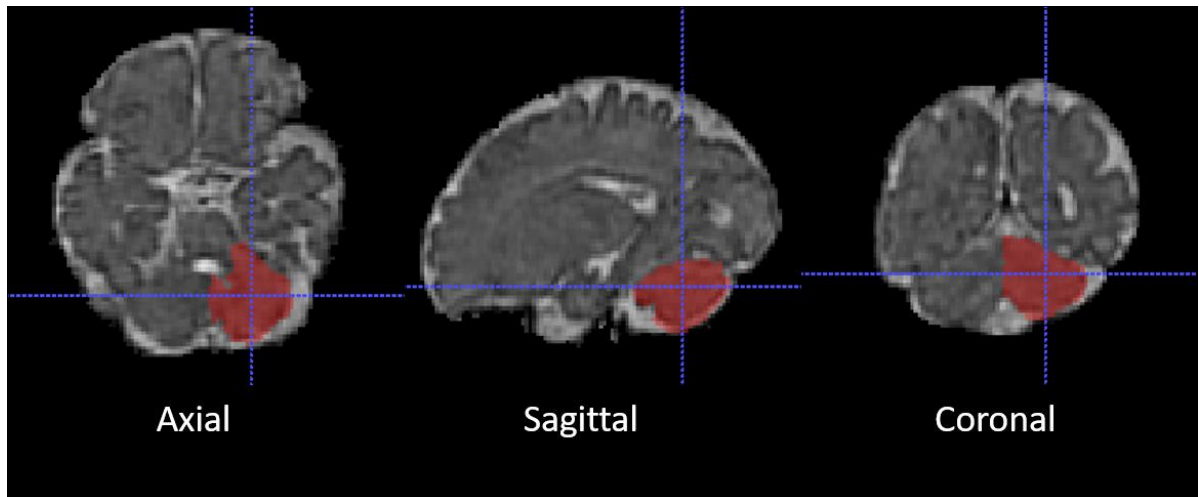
The registered template label into the subject space. This figure shows the linearly registered left cerebellum label using ANTs. The reconstructed 3D fetal brain volumes were skull-stripped. The orientations were transformed into the same image orientation of the fetal brain atlas as the original acquisitions of the MRI scans were oriented based on the position of mothers' bodies in the scanner. The manual and automatic cerebellum and thalamus segmentations were then performed on the processed reconstructed 3D volumes.
